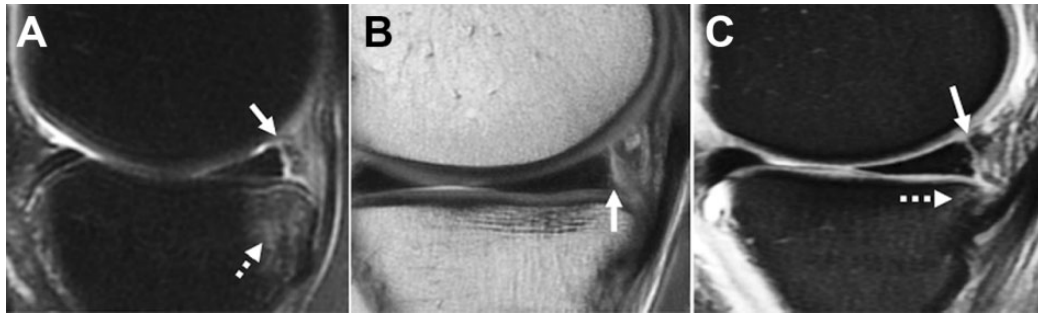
Magnetic resonance imaging of a ramp lesion in the sagittal plane. (A) Ramp lesion (arrow) defined as vertically oriented fluid signal intensity undermining the posterior horn of the medial meniscus at the meniscocapsular junction. Note the bone marrow edema pattern (dotted arrow). (B) Ramp lesion (arrow) on proton density imaging demonstrating intact medial compartment cartilage (modified Noyes score 0). (C) Subtle ramp lesion (arrow) with a faint bone marrow edema pattern (dotted arrow).
